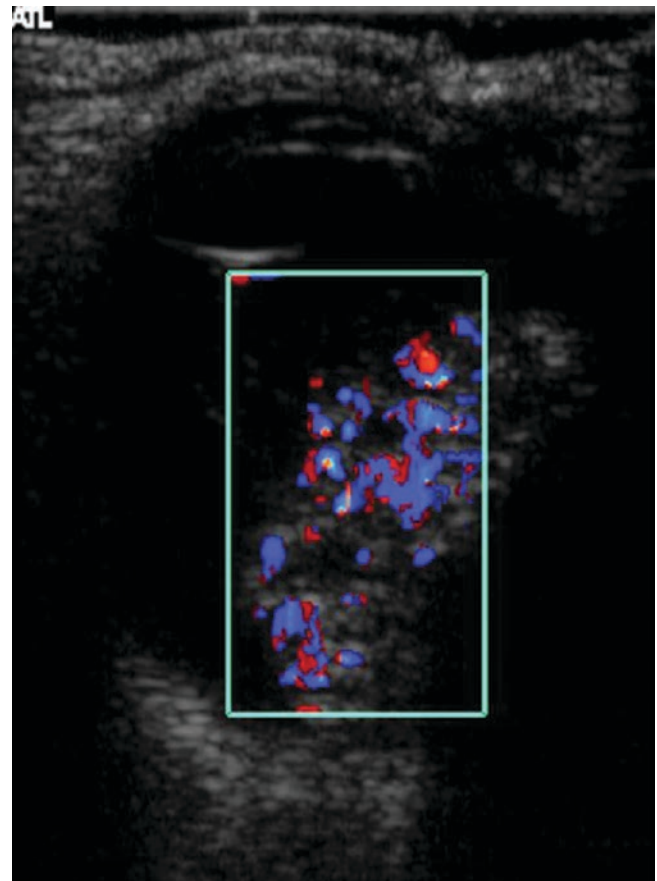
Retinoblastoma. Colour Doppler ultrasound image demonstrates hypervascularity within the tumour
